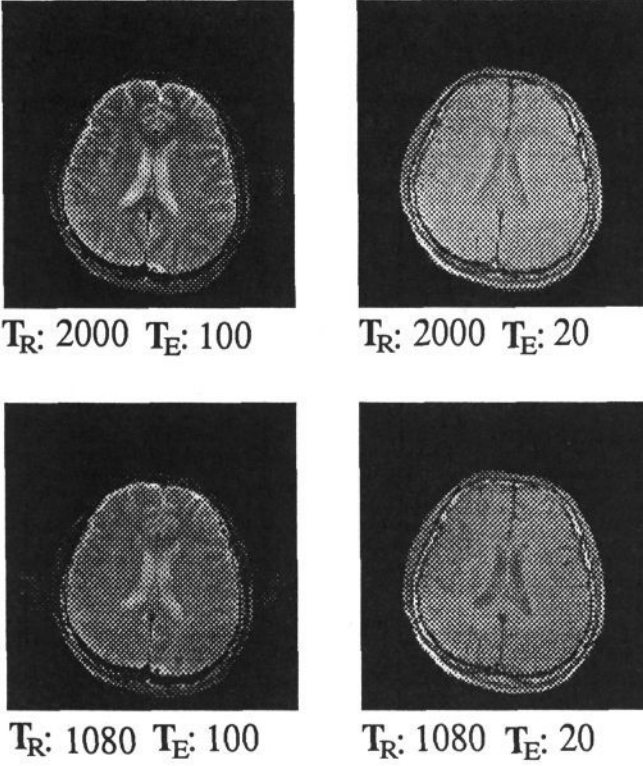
MR images used in building the imaging model. 8 slices for each set of T_R and T_E .
